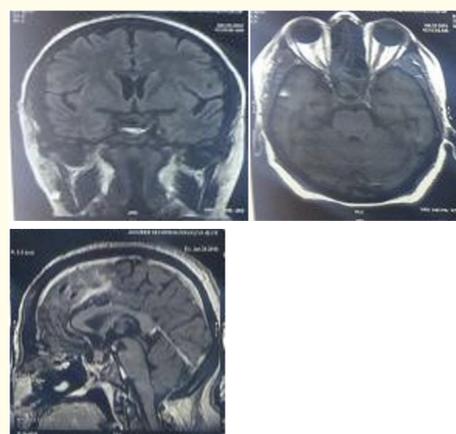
Postoperative MRI done after endoscopic transnasal transphenoidal excision.
